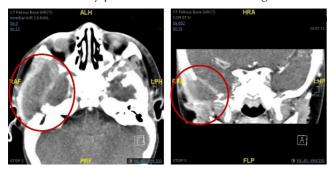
HRCT temporal bone(Contrasted, axial and coronal view) showed there was a large rim enhancing hypoechoic lesion on the right side of the infratemporal fossa, measuring 4.8x 2.3x1.9cm with the epicentre of the lesion at the squamous part of the right temporal bone with surrounding meningeal enhancement.
